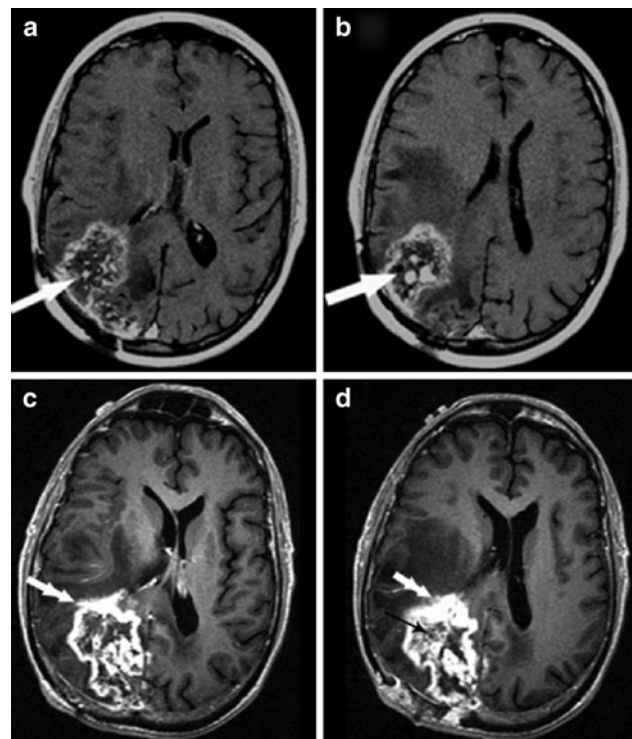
a–b T1-enhanced MRI in right parietal therapy-induced cerebral necrosis (TCN) shows “Swiss cheese/soap bubble” pattern of internal enhancement (arrows). There is also mass effect. c–d T1-enhanced MRI in another patient with right parieto-occipital TCN shows the “spreading wavefront” pattern of peripheral enhancement (double arrows) and the internal pattern of “Swiss cheese/soap bubble” enhancement (black arrow). There is also mass effect anteriorly and laterally. The FLAIR image showed cortical atrophy in the occipital lobe in the region of the observed enhancement
